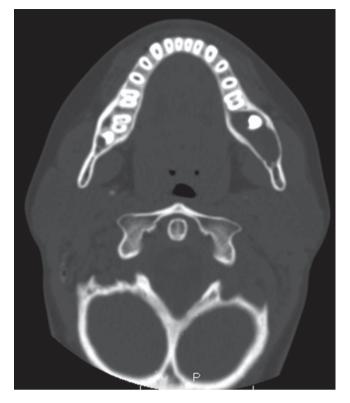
Axial computed tomography (CT) scan of left mandible showing radiolucent lesion with intact cortex and minor buccal and lingual cortical expansion
